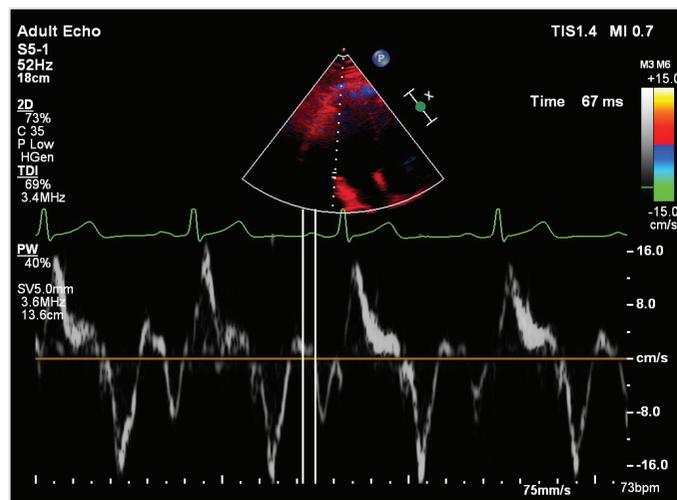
Evaluation of atrial conduction times with Doppler echocardiography
